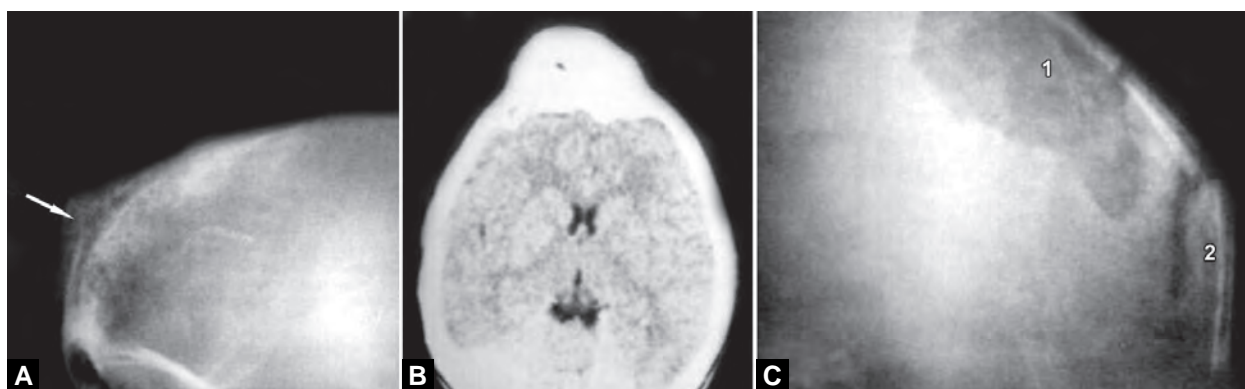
to C: (A) CT showing the large olfactory groove meningioma. (B) Note the involvement of the ethmoid sinuses by the tumour. (C) Post-operative skull X-ray shows that the bone flap occupies the region of the resected tumour. Arrow shows the site from where the partial-thickness split cranial graft was taken
